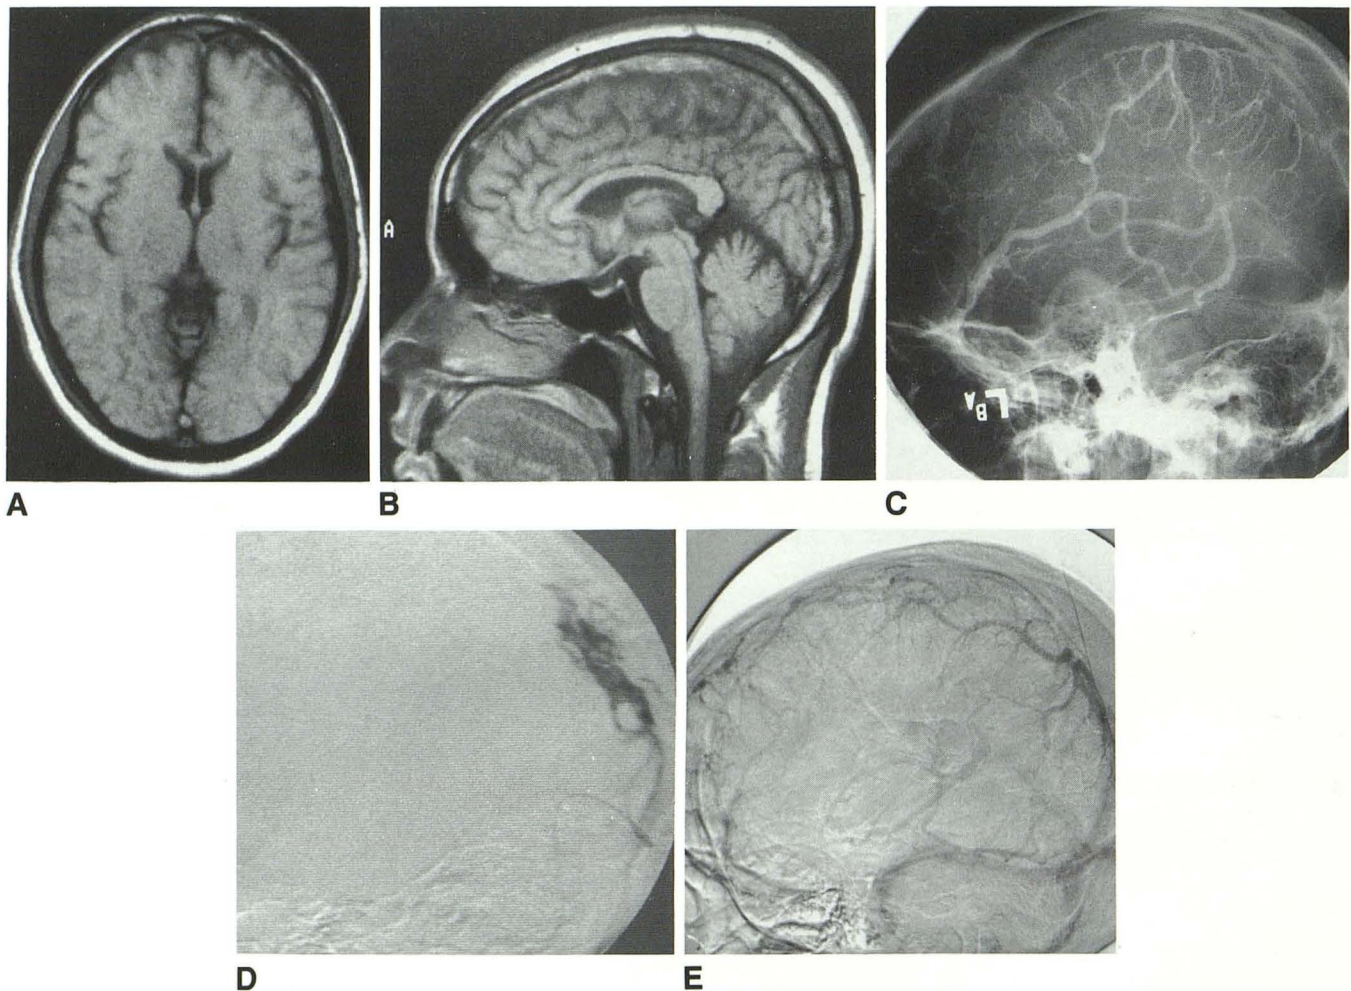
A* and *B*, MR shows increased intensity of superior sagittal sinus on T1-weighted images 550/30/2 (TR/TE/excitations). *C*, Venous phase of left carotid angiogram shows nonopacification of superior sagittal sinus. *D*, Selective superior sagittal sinus digital venography shows multiple filling defect in the posterior one third of the sagittal sinus due to thrombi. *E*, Venous phase of follow-up carotid angiogram shows good opacification of the posterior-superior sagittal sinus and some opacification of the anterior one third of the sinus.
